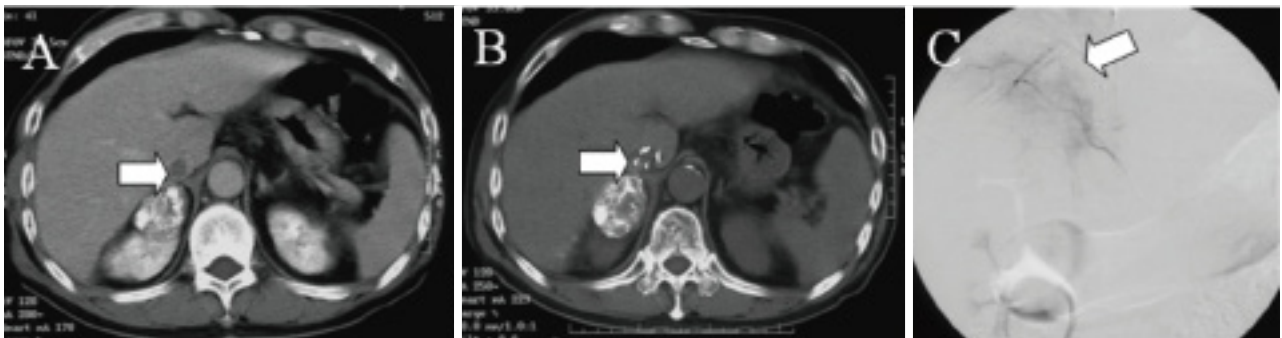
A: An inferior vena cava thrombus (arrow) detected during computed tomography; B: A filter (arrow) placed into the inferior vena cava; C: A faint tumor (arrow) seen in the right adrenal gland on a right middle adrenal arteriogram.
